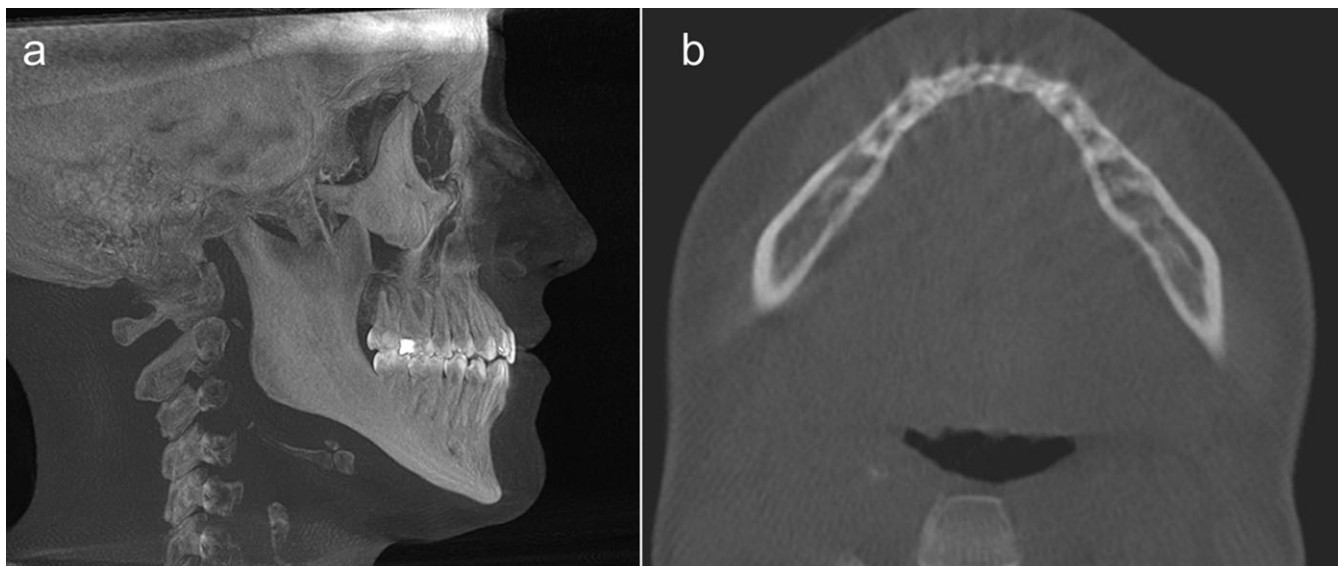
Maximum intensity projection lateral cephalometric image reformatted from CBCT data (a) demonstrating anterior open bite and excessive inter-incisal angle between the maxillary and mandibular incisors requiring a change in the position of the anterior mandibular incisors. The axial image (b) shows a very thin alveolar bone width associated with the roots of the mandibular incisor teeth.
